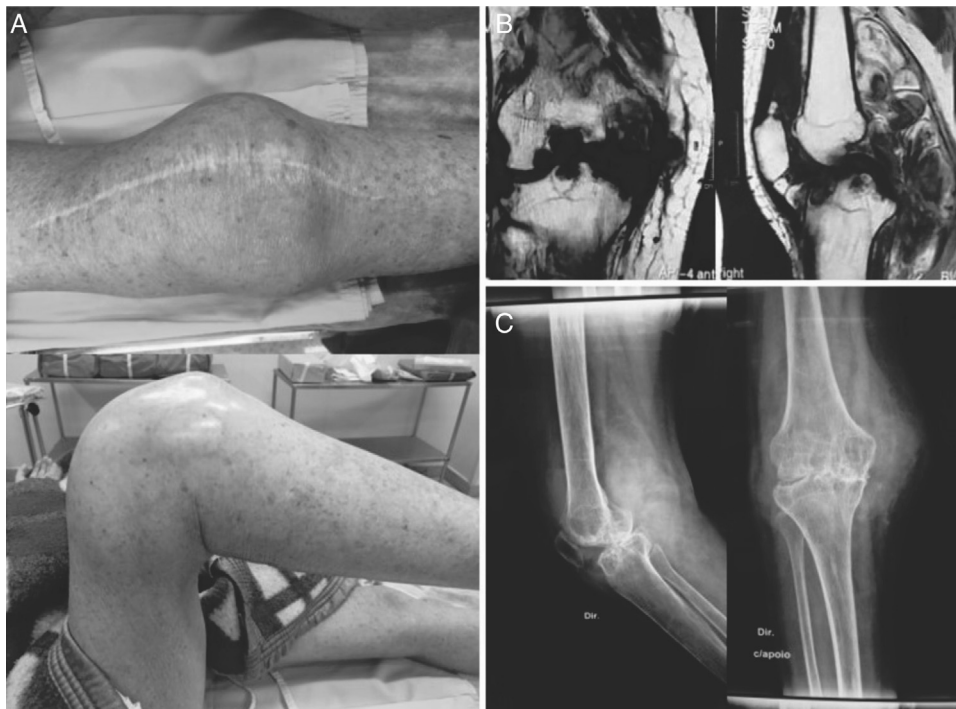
Clinical aspect (A), magnetic resonance imaging (B) and radiographs (C), which demonstrate diffuse synovitis, arthrosis, and bone cysts.
